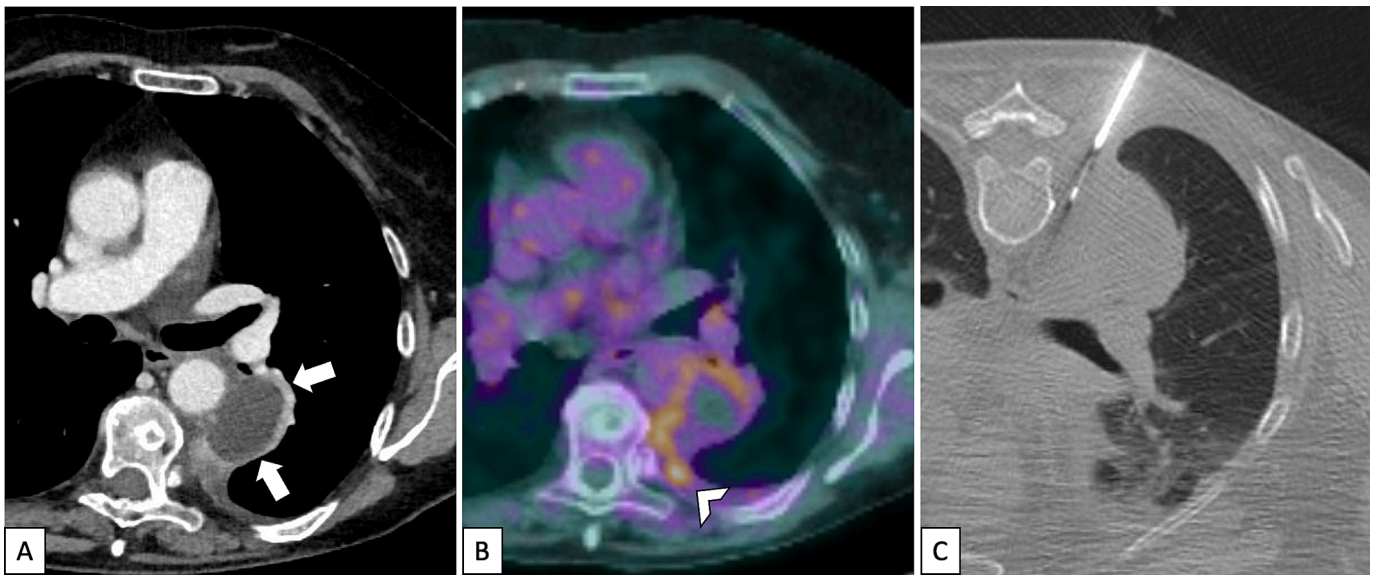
A. Contrast-enhanced CT of a heterogeneous mass with large hypodense core and peripheral enhancing tissue abutting the left paravertebral region and posterior mediastinum (arrows). B. ^{18}F -FDG PET/CT showed abnormal peripheral metabolic activity (arrowhead), suspected of malignancy. C. The patient was referred for CT-guided transthoracic needle biopsy. The procedure was performed by comparing contrast-enhanced CT, functional imaging, and intraprocedural plain low-dose scans side by side to target the area with the highest metabolic uptake. The biopsy suggested epithelioid mesothelioma, later confirmed by surgery.
